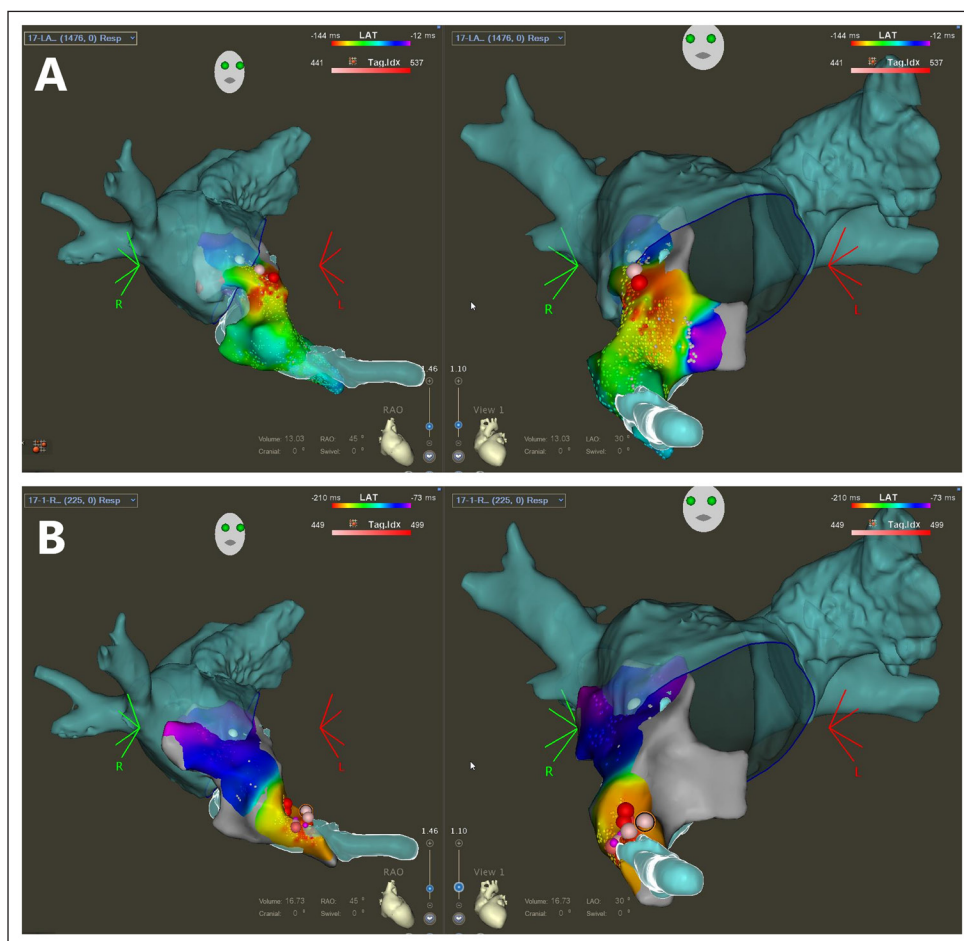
Three-dimensional electroanatomic activation mapping overlaying CT reconstructed images of the left atrium during atrial tachycardia (AT). (A) During the first AT with tachycardia cycle length (TCL) 370 ms, AT was mapped to the earliest site near the ostium of the left atrial diverticulum. Ablation resulted in termination of the first AT and initiation of the second AT. (B) During the second AT with TCL 315 ms, AT was mapped to the earliest site inside the diverticulum. Ablation at the site resulted in termination of the second AT. Left panels: right anterior oblique view; right panels: left anterior oblique view
